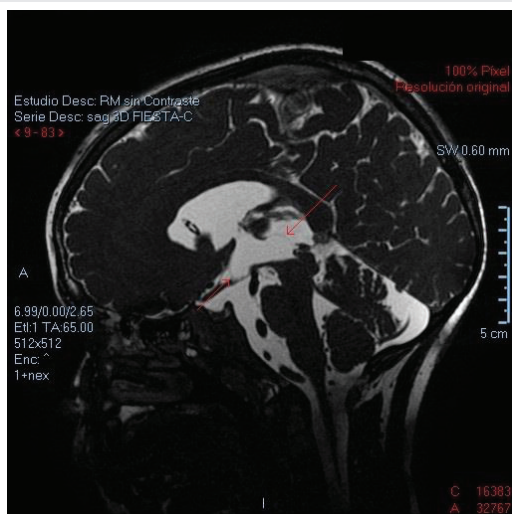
3D-FIESTA MRI sequence. The anterior, posterior and superior limits (indicated by arrows) of the cyst of the third ventricle are observed with submillimeter precision.
